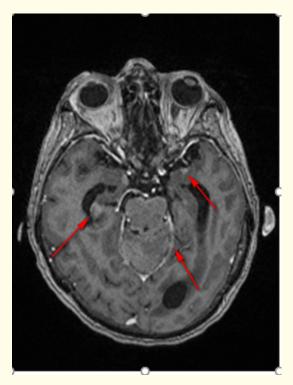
Axial T1 postcontrast brain MRI abnormal enhanacement shadow (arrow pointed).
